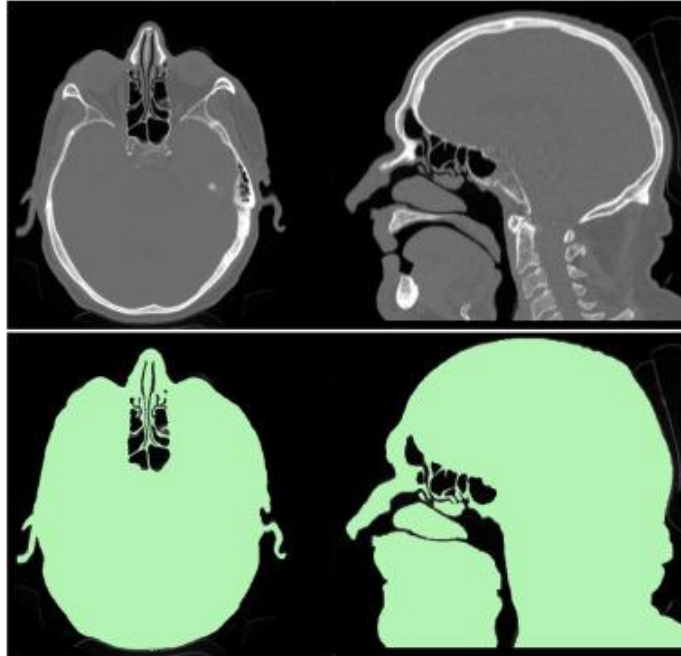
Example CT images (high) and their segmentation (low) obtained by setting a threshold value of HU= -281, after removal of the connection between mouth and epiglottis. Black corresponds to the aerial volume.
